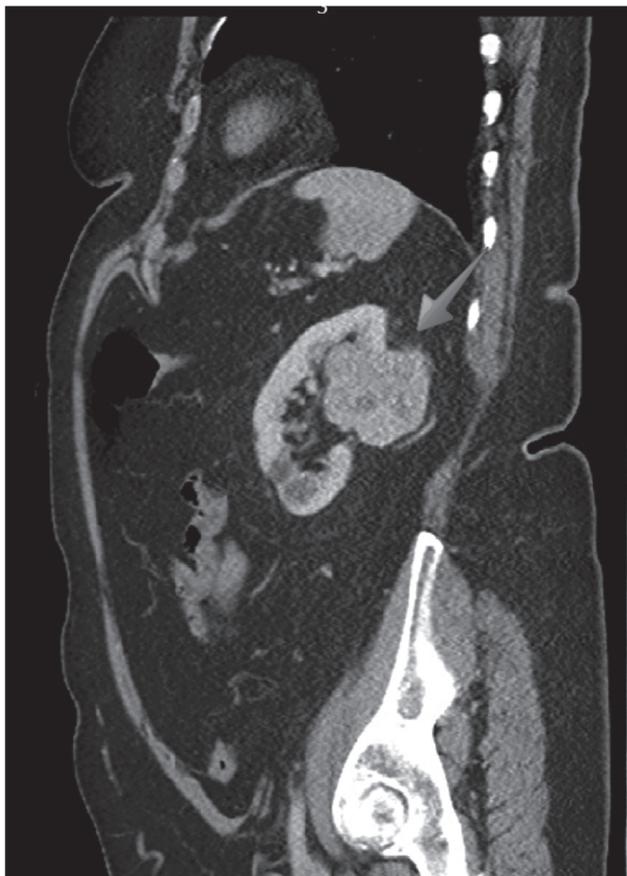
Sagittal view abdomen CT scan, showing a large nonhomogeneous mass lesion in the mid-pole area
